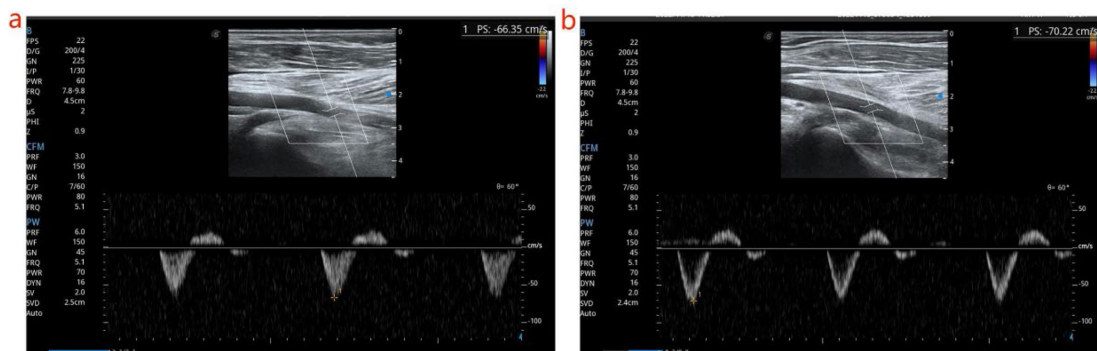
Hemodynamic results of the popliteal artery were detected by B-ultrasound. (a) The results prior to the rolling manipulation are displayed. (b) Changes in blood flow after rolling manipulation.
